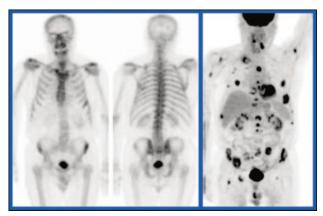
A striking example of the comparison of a negative ^{99m}Tc-MDP bone scan (left) and positive ¹⁸F-FDG PET (right) in a patient with lung cancer.
